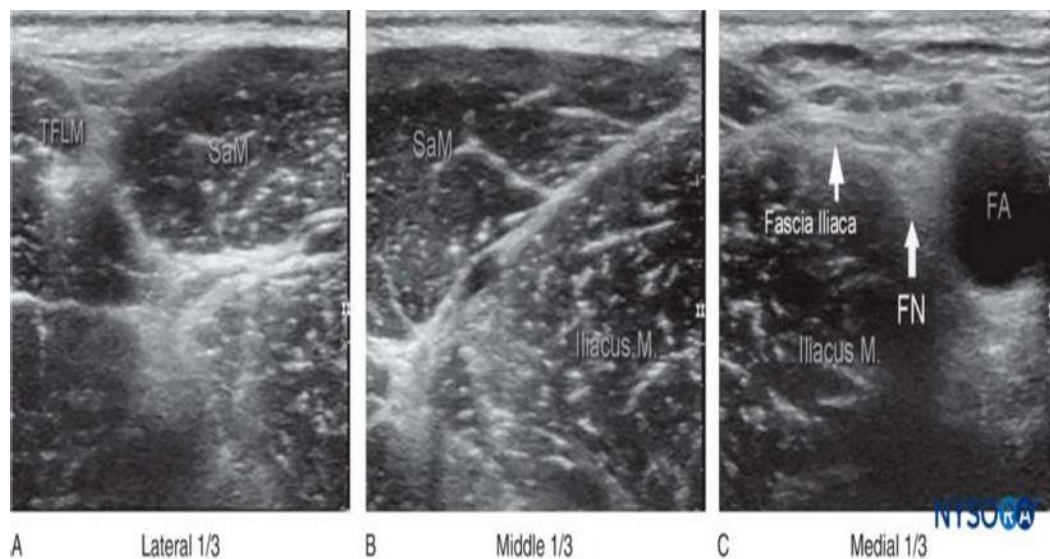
Ultrasound anatomy of the inguinal crease area. From lateral to medial, shown are the tensor fasciae lata muscle (TFLM), SM, Iliaca muscle, Fascia Iliaca, Femoral nerve (FN) and Femoral artery (FA)
